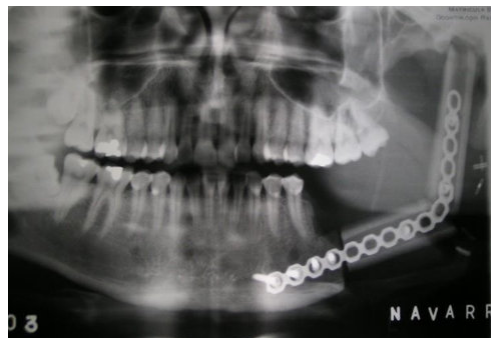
Immediate post-surgical panoramic radiograph where it is possible to appreciate the fibula bone graft adapted to the mandibular body, angle and condyle, fixed using a 2.4 mm mandibular reconstruction plate.
